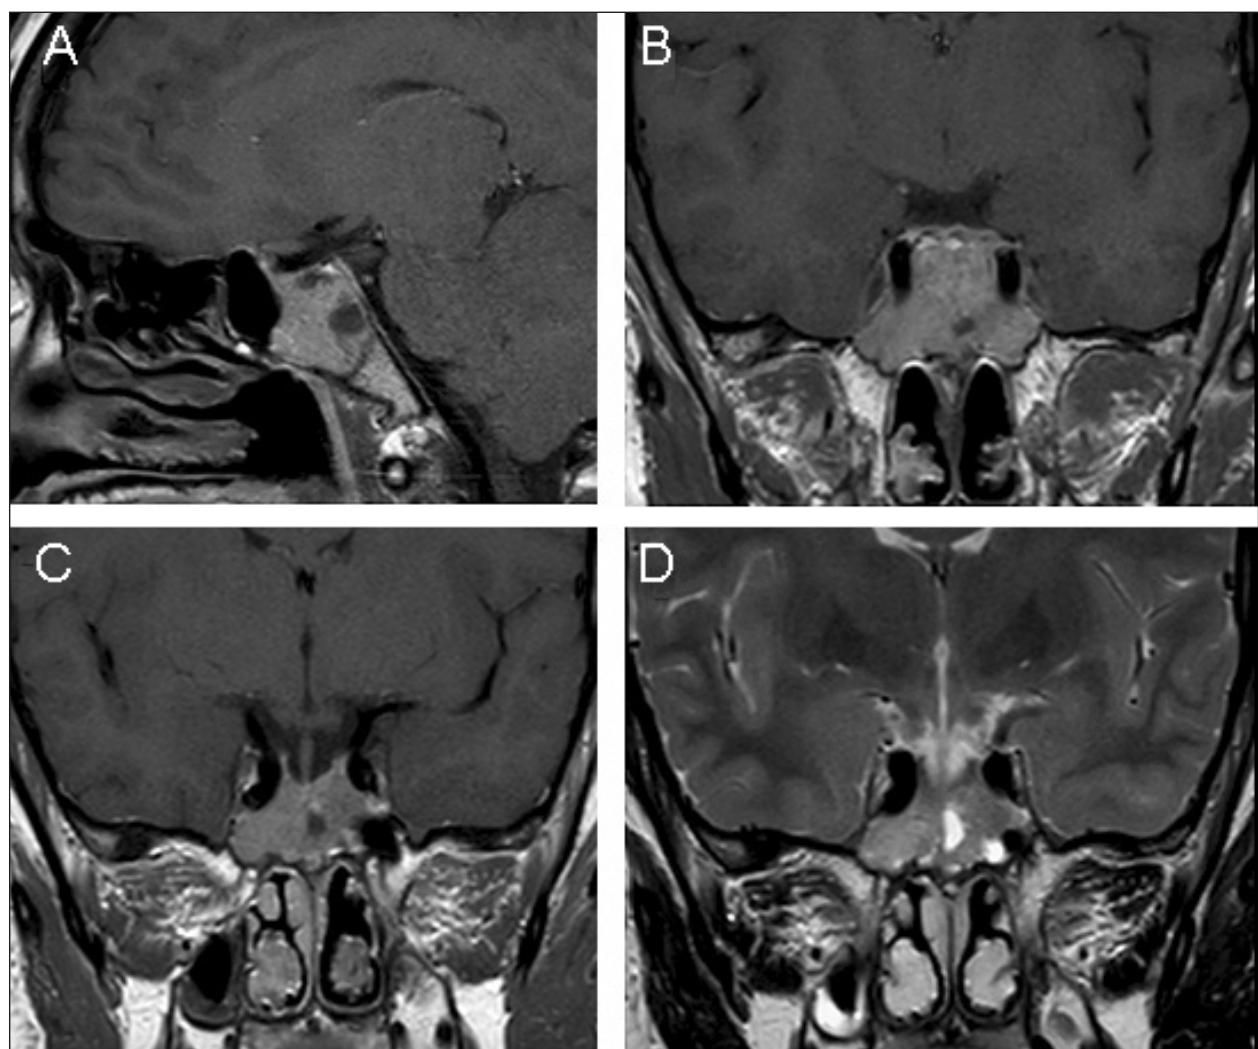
Magnetic resonance imaging (MRI) of the sellar and parasellar regions. (A) Sagittal T1-weighted; (B) coronal T1-weighted; (C) coronal contrast-enhanced T1-weighted; and (D) coronal T2-weighted.
